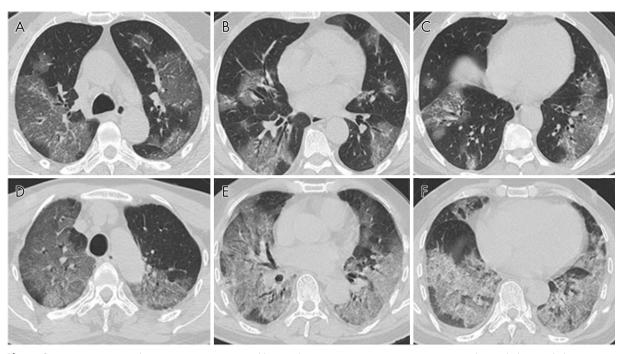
A-C, Noncontrast chest CT images in a 56-year-old man with severe COVID-19 pneumonia. CT images show multiple ground-glass opacities in multiple lung segments, and the CT-SS is 28. *D-F*, Noncontrast chest CT images in a 69-year-old man with severe COVID-19 pneumonia. CT images show multiple ground-glass opacities and septal thickening; the imaging manifestation is the so-called white lungs; the CT-SS is 35.
